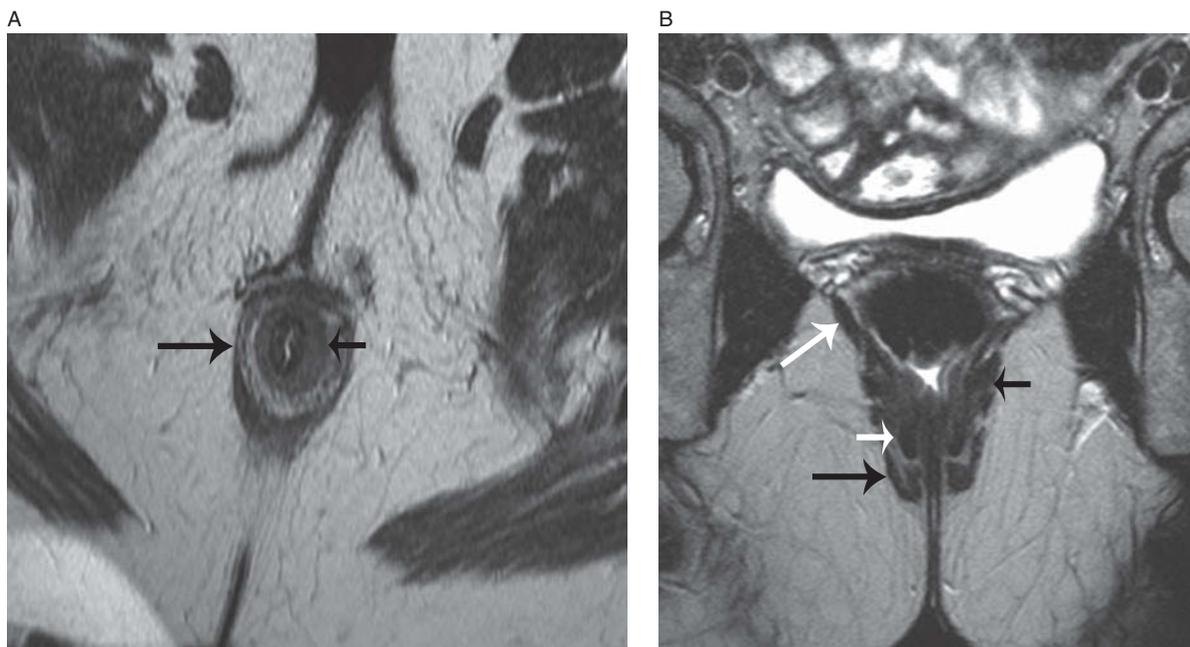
Normal anatomy of sphincter complex. Axial T2-weighted image (A), long arrow on the external anal sphincter (EAS) and short arrow on the internal anal sphincter (IAS). Coronal T2-weighted image (B), long arrow on EAS, short white arrow on IAS, short black arrow on puborectalis (PR), and long white arrow on iliococcygeus (IC) muscle.
